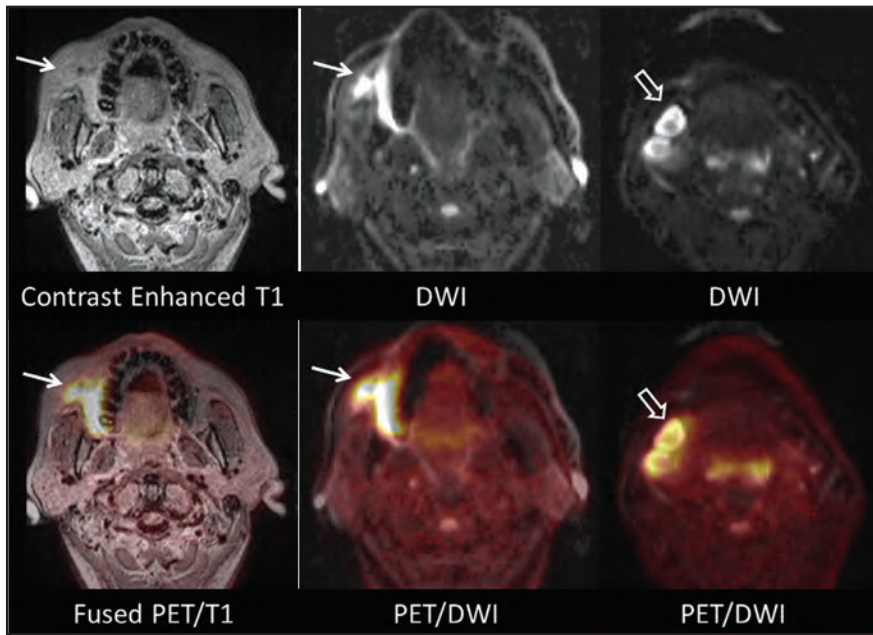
Buccal cancer. Images depict a metabolically active tumor in the right buccal space (arrows), which also is well shown on the DWI and ADC map to restrict diffusion. The patient had biopsy-proven metastatic involvement of 1b lymph nodes within the right submandibular space (open arrows).
